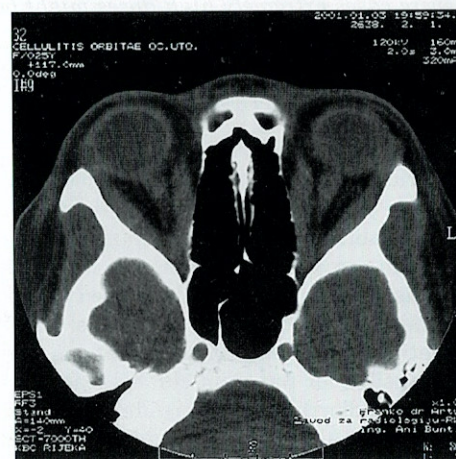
Orbital axial CT scan prior to therapy showing bilateral proptosis and enormous extraocular muscles enlargement
